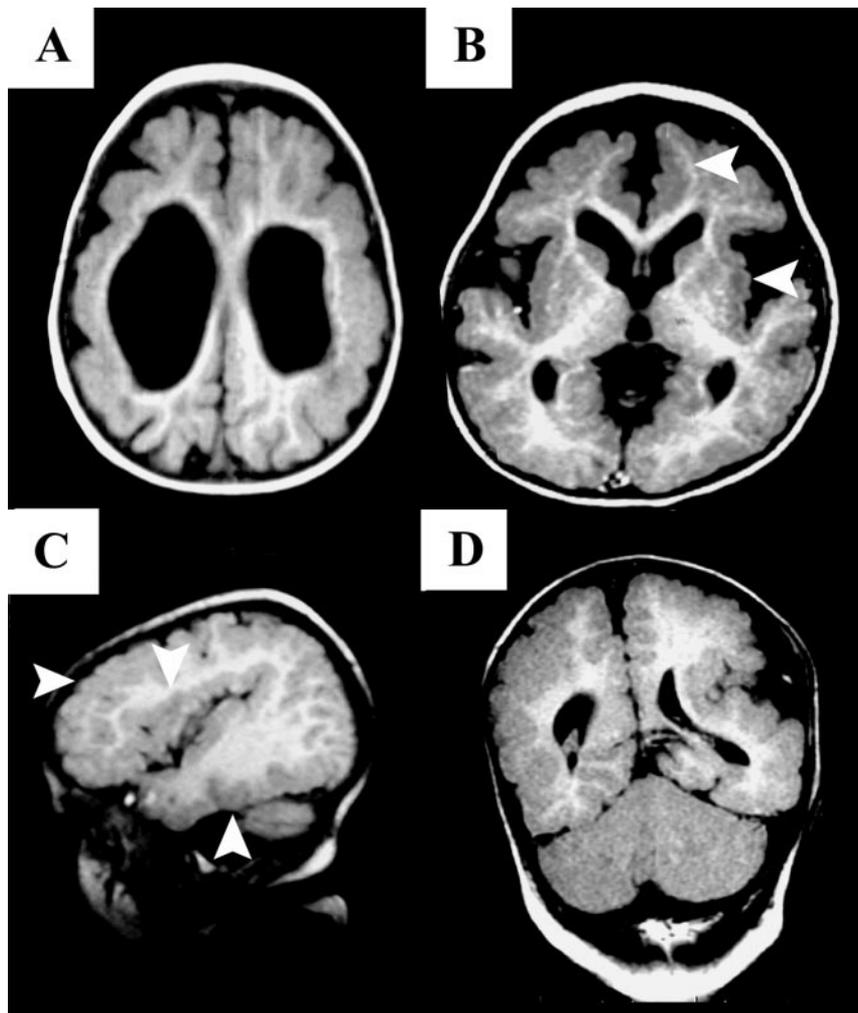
Representative T1-weighted MRI from patients with bilateral generalized polymicrogyria. (A) Axial image from Patient 3 at 13 months of age. The apparent increase in cortical thickness and irregular, scalloped gray-white junction indicate the presence of polymicrogyria in almost all regions of cortex. Markedly enlarged ventricles and reduced white matter volume are also evident. (B) Axial image from Patient 4 at 11 months of age. Generalized polymicrogyric cortex is apparent in this image, including the perisylvian and medial frontal regions bilaterally (indicated on left by arrowheads). (C) Sagittal image from Patient 7 at 2 years of age. The frontal, inferior temporal, and perisylvian regions of cortex are most obviously affected (arrowheads). (D) Coronal image from Patient 5 at 4 months of age. In addition to generalized polymicrogyria, this image also demonstrates that the posterior end of the left Sylvian fissure is “uncovered” and abnormally oriented.
